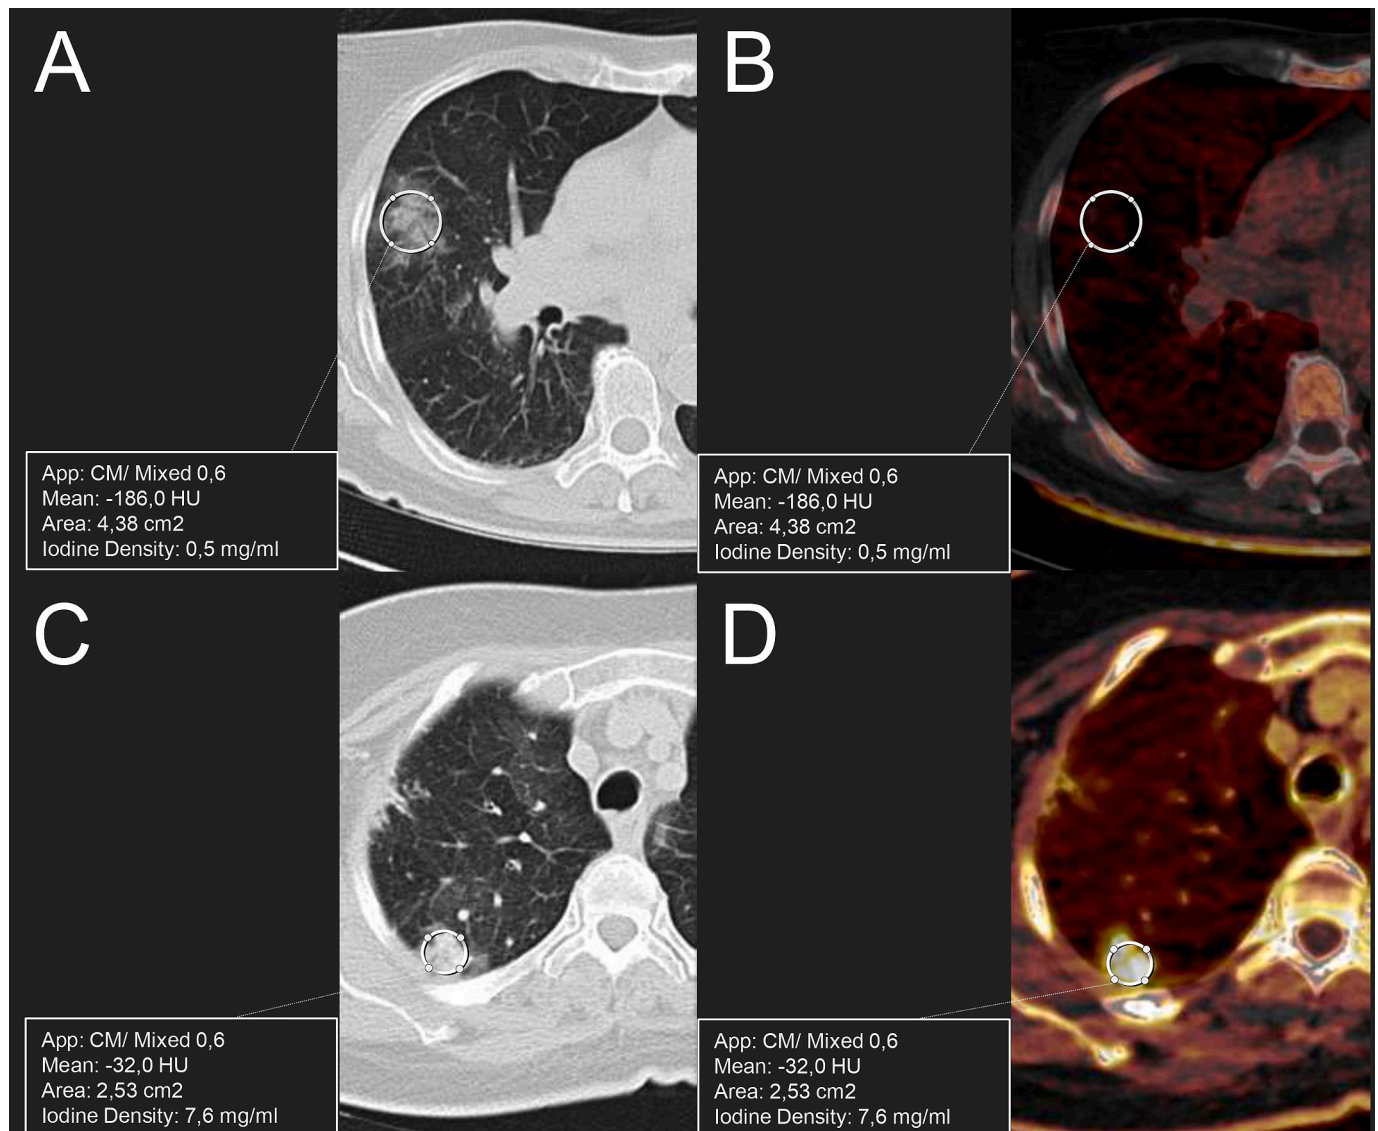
Examples of lung injuries with normal and elevated iodine levels. Examples of post-BPA lung injuries with normal and elevated intralesional iodine levels. (A-B) Non-contrast dual-energy CT scan of a new-onset pulmonary injury with normal iodine levels in a 52-year-old female patient presenting with worsening dyspnea after BPA. (A) Axial lung window image shows a new-onset ground-glass lung injury in the lateral segment of the middle lobe. A circular ROI encompassing at least 80 % of the lesion is demonstrated. (B) Axial iodine map image at the same level as (A) reveals no enhancement within the new-onset lung injury in the middle lobe. Intralesional iodine concentration is low (0.5 mg/mL). (C-D) Non-contrast dual-energy CT scan of a new-onset lung lesion with elevated iodine levels in a 68-year-old male patient experiencing intraprocedural hemoptysis. (C) Axial lung window image demonstrates a new-onset lung injury with mixed ground-glass and consolidation components in the apical segment of the right upper lobe. A circular ROI encompassing at least 80 % of the lesion is displayed. (D) Axial iodine map image at the same level as (C) shows qualitative and quantitative elevations in intralesional iodine concentration compared to the surrounding normal parenchyma, with a measured value of 7.6 mg/mL.
